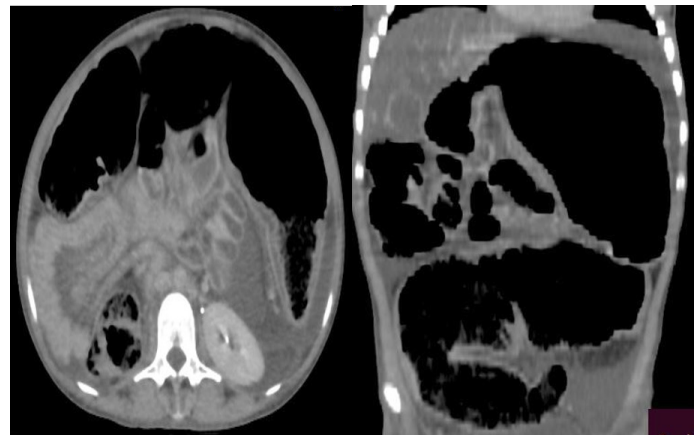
Axial and coronal section of abdominopelvic CT-scan shows significant colonic dilatation above transition zone and collapsed rectum below and the entire colon filled with gas.
